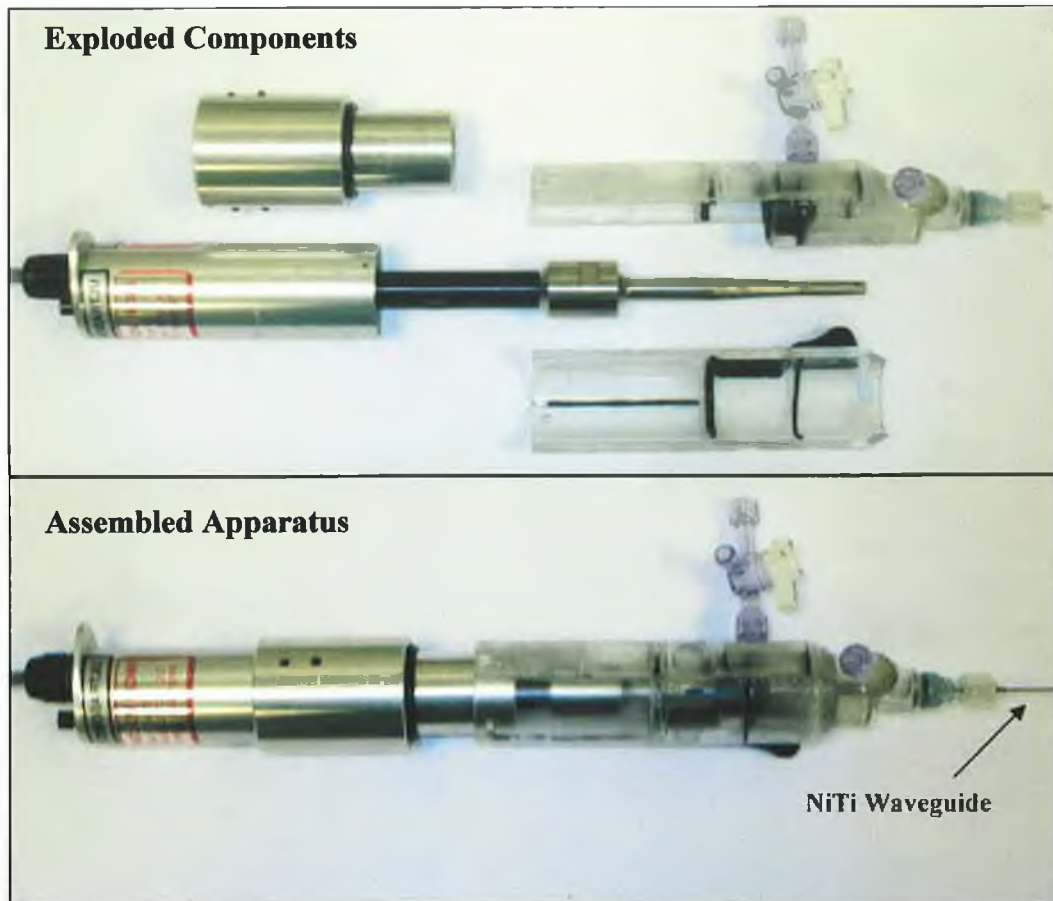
Image of final ultrasonic wire waveguide apparatus in its housing with catheter emerging.
